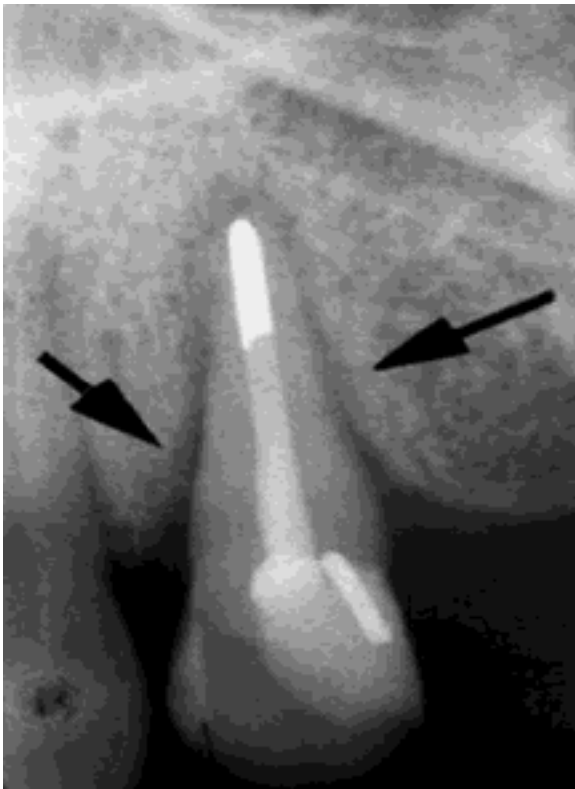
Widening of the periodontal space as observed on radiographs.
